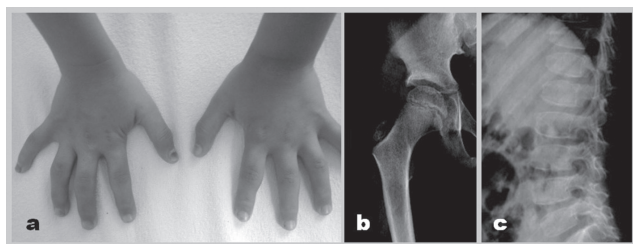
a) Clinical photographs and X-ray films of patient 1 show an enlargement of the proximal interphalangeal joints, b) irregular acetabular roof, c) flattening and anterior beaking on the thoraco-lumbar spine
